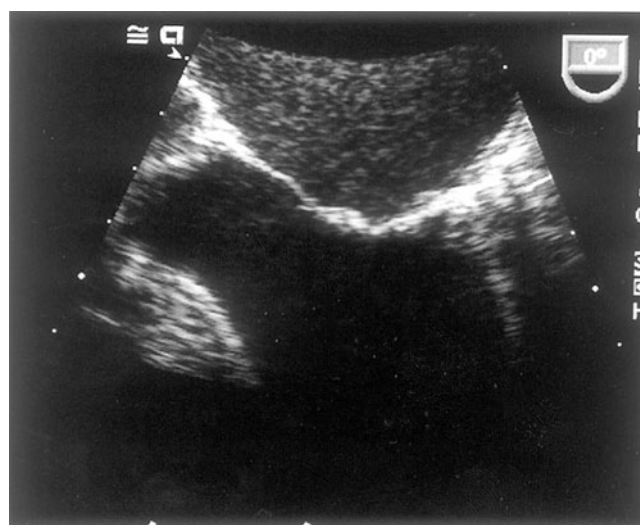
Echocardiogram of a patient with ischemic mitral regurgitation and apical systolic leaflet tenting.
